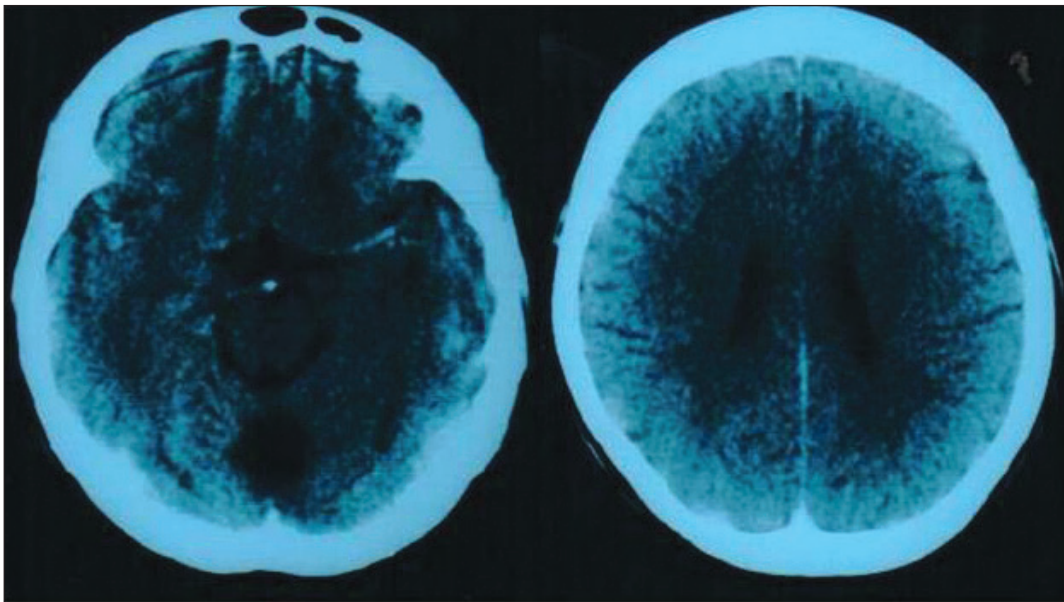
Postoperative computed tomography was performed after the first surgery in 1988. Note the postoperative changes, such as the area of encephalomalacia at the middle line of vermian.
